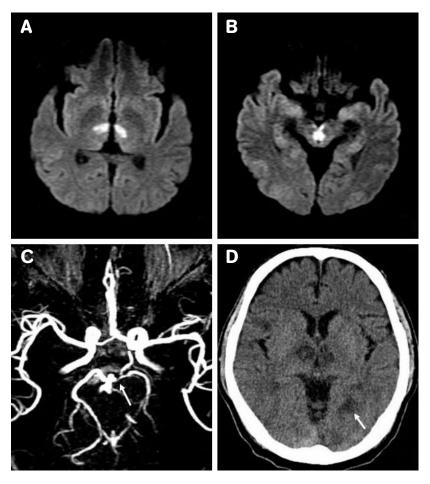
MR diffusion-weighted image at 6 hours of symptom onset denoted the restriction of water diffusion over bilateral paramedian thalami (A) and rostral midbrain (B). MR angiography (C) demonstrated a focal stenosis over the first segment of left posterior cerebral artery (white arrow). Brain computed tomography on three days later (D) showed hypodensity lesions at bilateral thalami as previously noted and a new-developed, poor-demarcated hypodensity lesion at left occipital lobe (white arrow).
